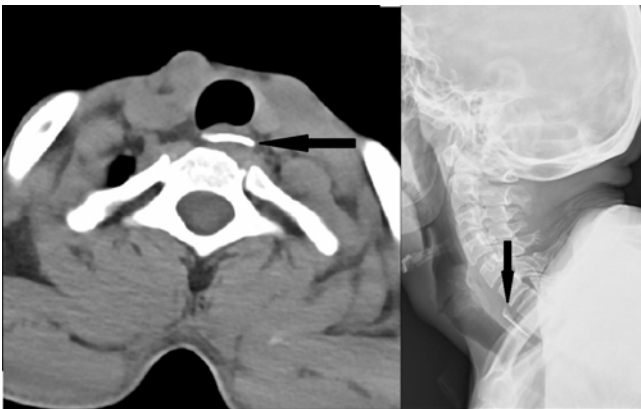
Radiological imaging of the piece of glass in computed tomography and X-ray
